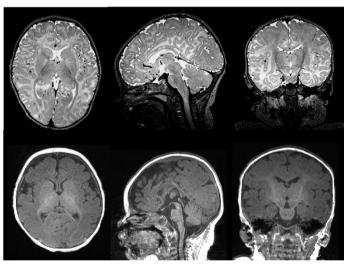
Raw T2-weighted images (top), raw T-1 weighted images (bottom)
